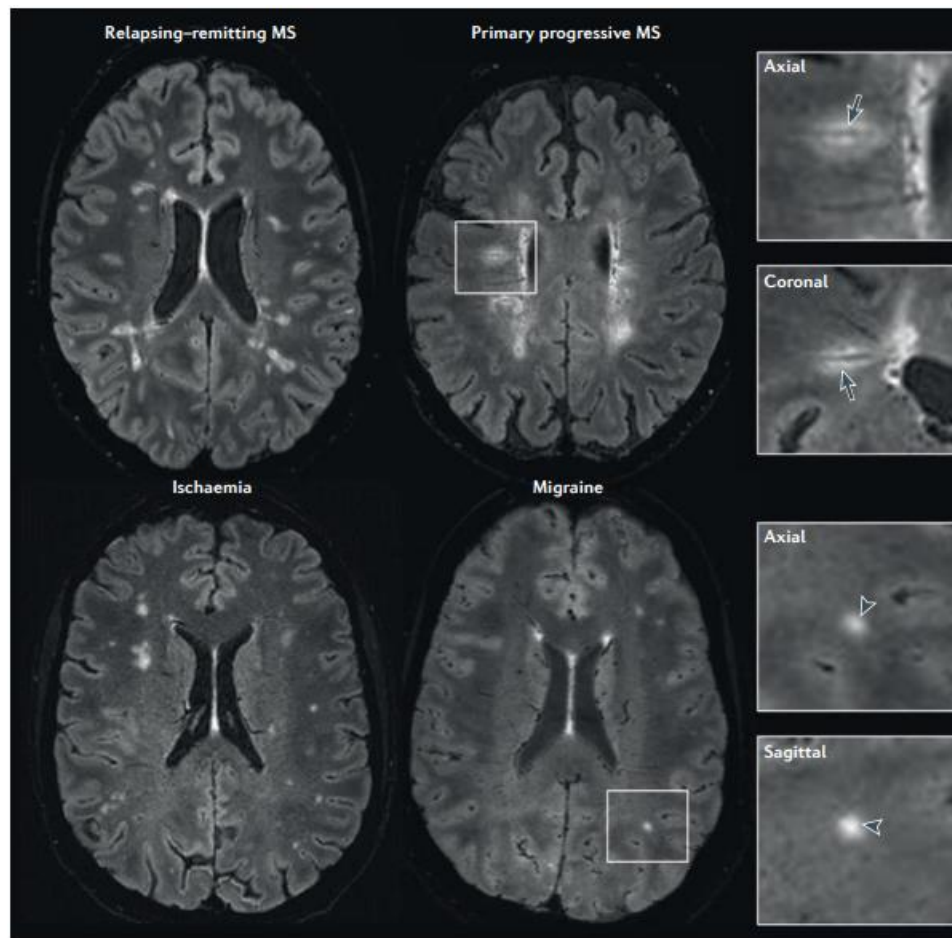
MRI detection of central vein sign in MS lesions. Figure reports 3T FLAIR* (combined T2*-weighted MRI and fluid-attenuated inversion recovery) MRI detection of brain in one patient with RRMS, one with PPMS, one with ischemia and one with migraine. The dark veins are present centrally in the lesions of MS patients, but not in ischemia and migraine patients. Arrows in magnified panels indicate lesions (Sati P et al., 2016).
